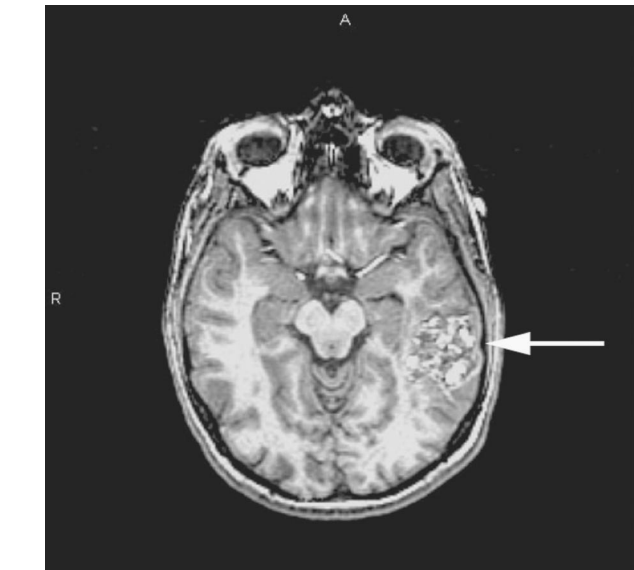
MRI appearance of CCM. Axial MRI view of the brain. Characteristic cavernous malformation lesion (marked with arrow) is seen within the left temporal lobe. The heterogeneous signal within the lesion is indicative of prior hemorrhage.
